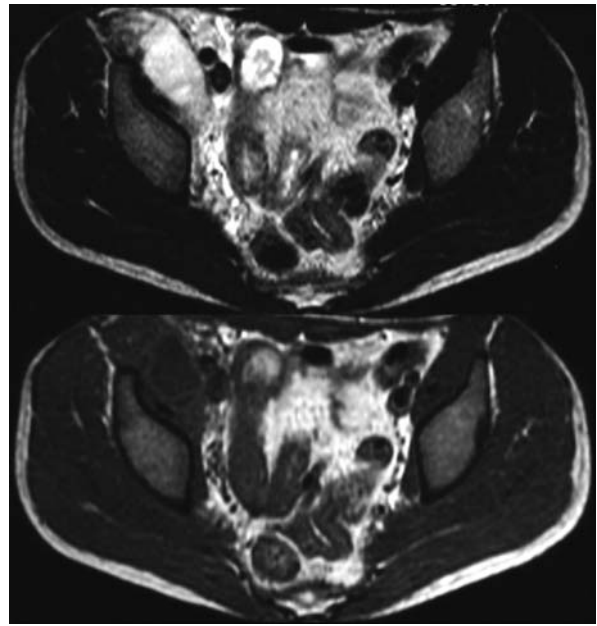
Magnetic resonance imaging of the abdomen and pelvis
